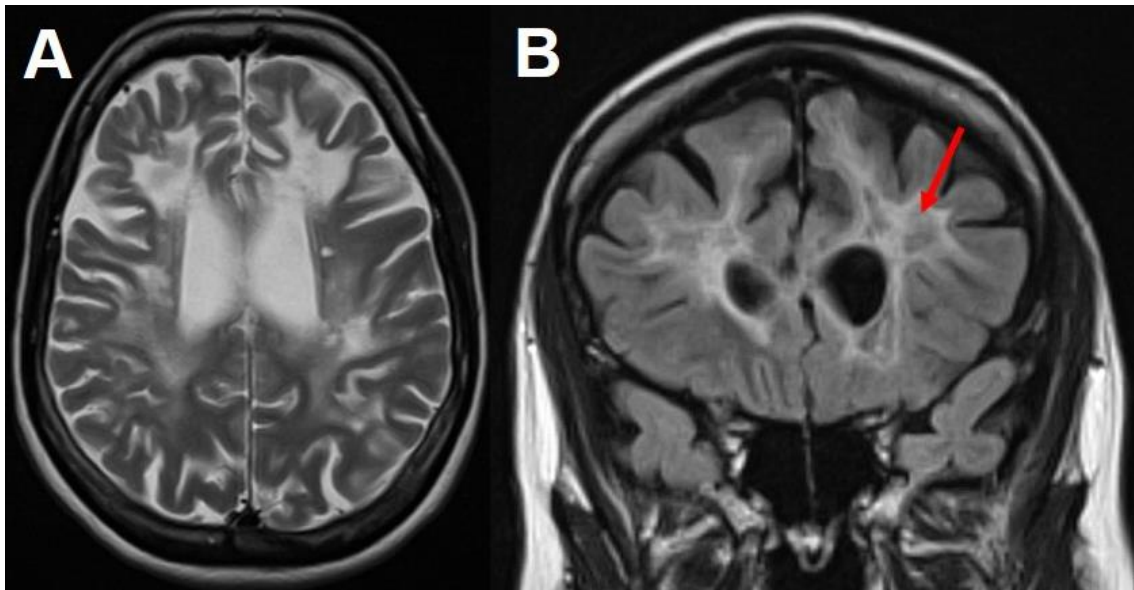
Brain MRI findings in a case of methylglutaconic aciduria (AUH-related leukoencephalopathy). The MRI pattern is characterized by prominent, diffuse T2 hyperintensity (A) combined with prominent T1 hypointensity (D), as seen by definition in demyelinating leukoencephalopathies. The typical sparing of the periventricular regions (B, red arrow) and the bilateral involvement of the middle cerebellar peduncles (E, red arrows) are also shown.
